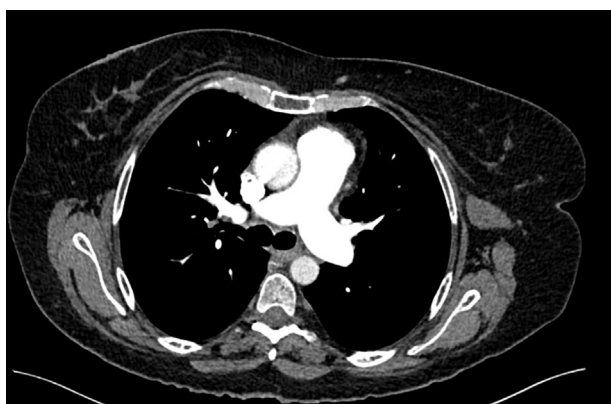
HRCT of the chest showing PA/aorta ratio > 1.
